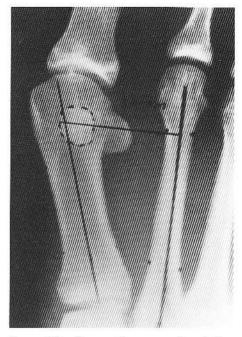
Preoperative x-ray of a hallux abductovalgus demonstrating the hallux abductus angle, the intermetatarsal angle, the tibial sesamoid position, and the tibial sesamoid second metatarsal distance.
